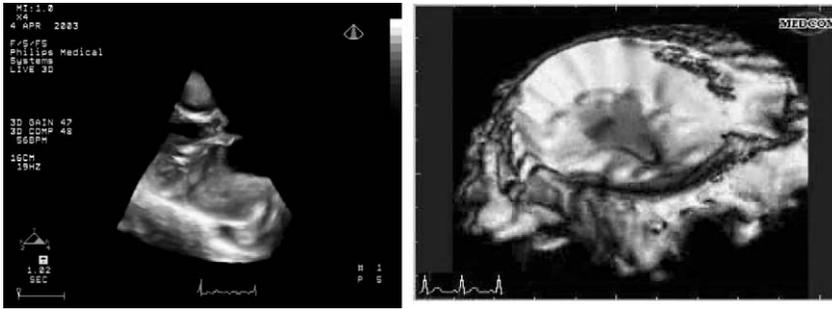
3-D echocardiography. *Left.* Aortic and mitral valve volume acquired using a 3-D real-time system. Image courtesy of Royal Philips Electronics (Eindhoven, The Netherlands). *Right.* 3-D volume of an atrioventricular valve with the color flow superimposed, acquired using a multiplane acquisition scheme. Image courtesy of MedCom GmbH (Darmstadt, Germany). Videos available at <http://www.die.upm.es/im/videos>.
